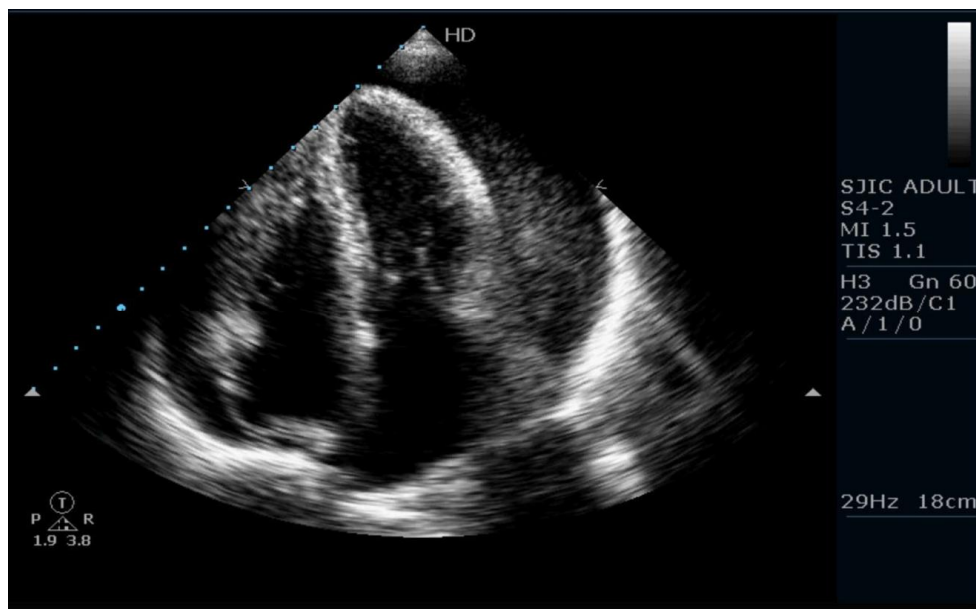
Large pericardial effusion seen in apical four chamber view
